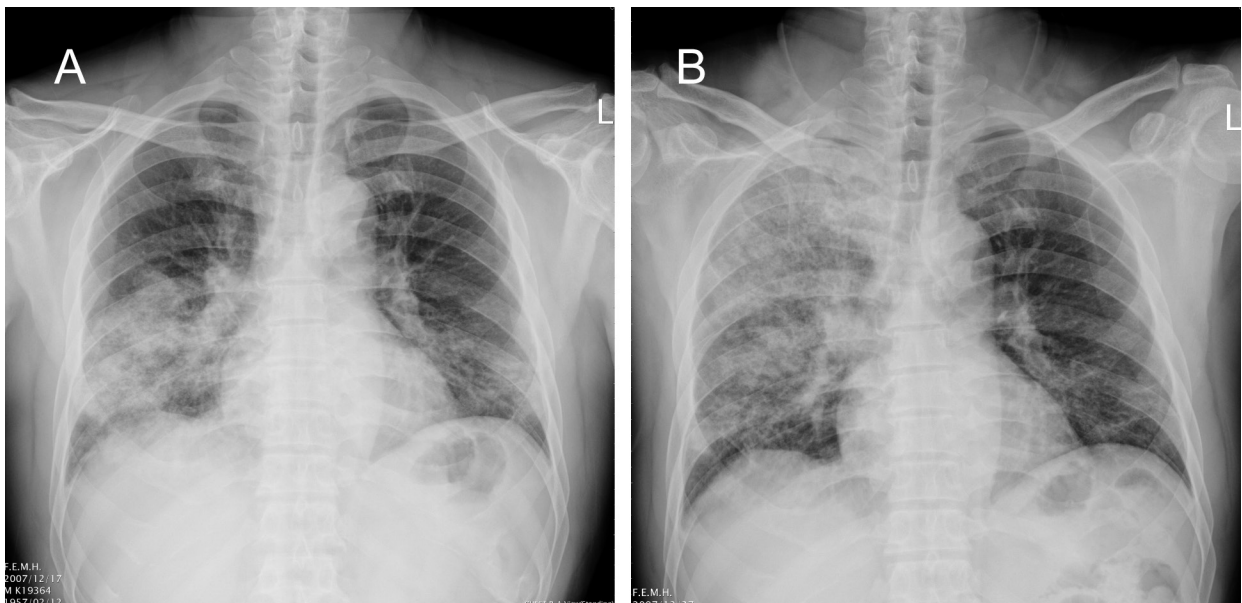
(A) Chest radiography reveals right lower lung consolidation. (B) Chest radiography showed progressing consolidation after 1 week.
